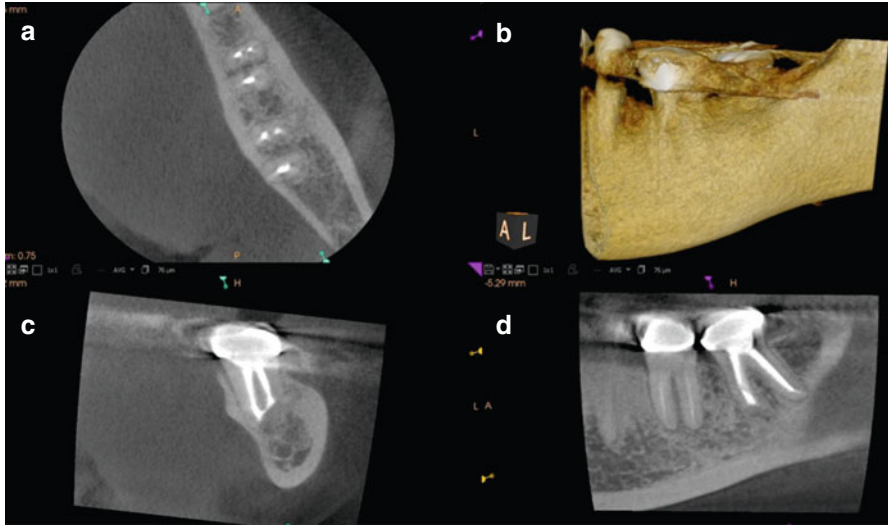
Continuation of case presented in Figs. 6.10 and 6.11: 18-month postoperative CBCT scan demonstrating complete remodeling of the defect and the buccal plates (a-d)
